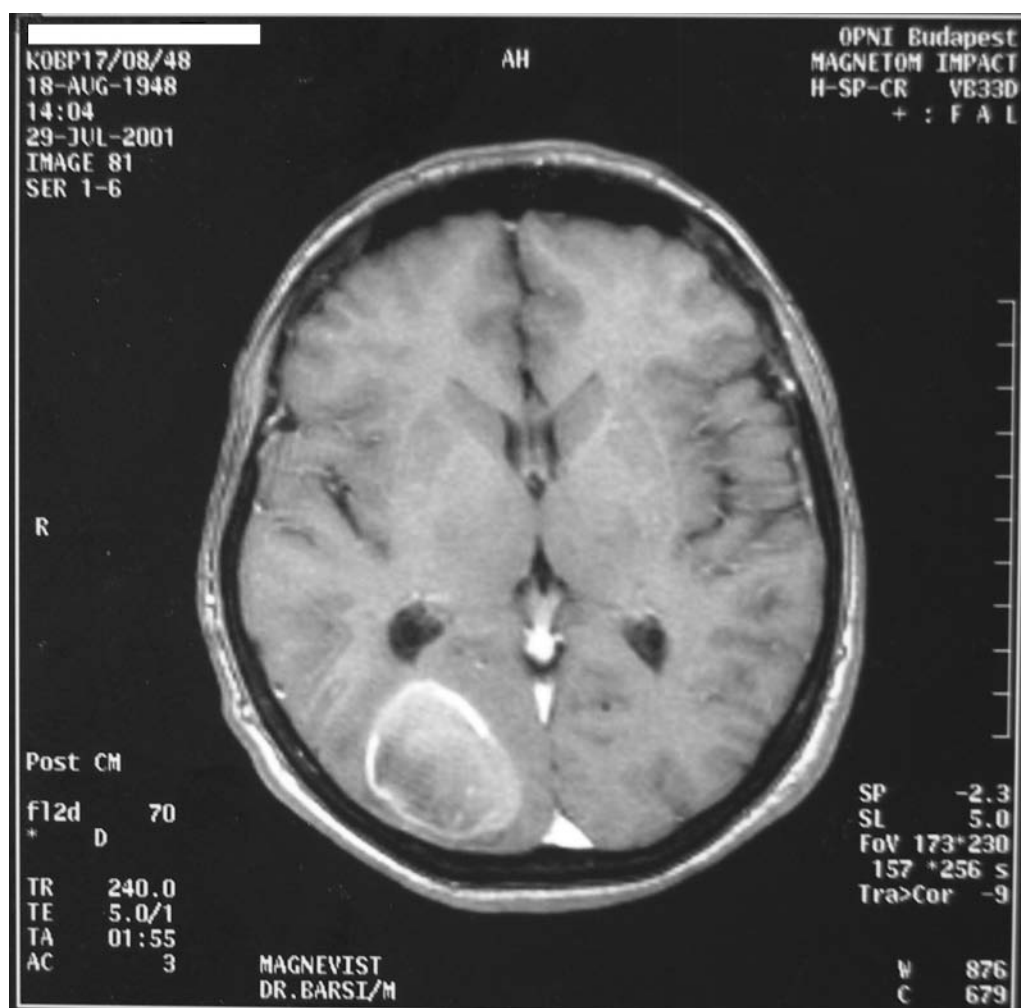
Anteroposterior computed tomography (CT) image of the brain metastasis from lung cancer in patient 2 before the treatment. The anteroposterior CT image of the brain shows on the right side a metastatic parieto-occipital tumor measuring $20 \times 30 \times 40$ mm before the combined treatment of radiotherapy and chemotherapy supplemented with deuterium depleted water (DDW) consumption.
